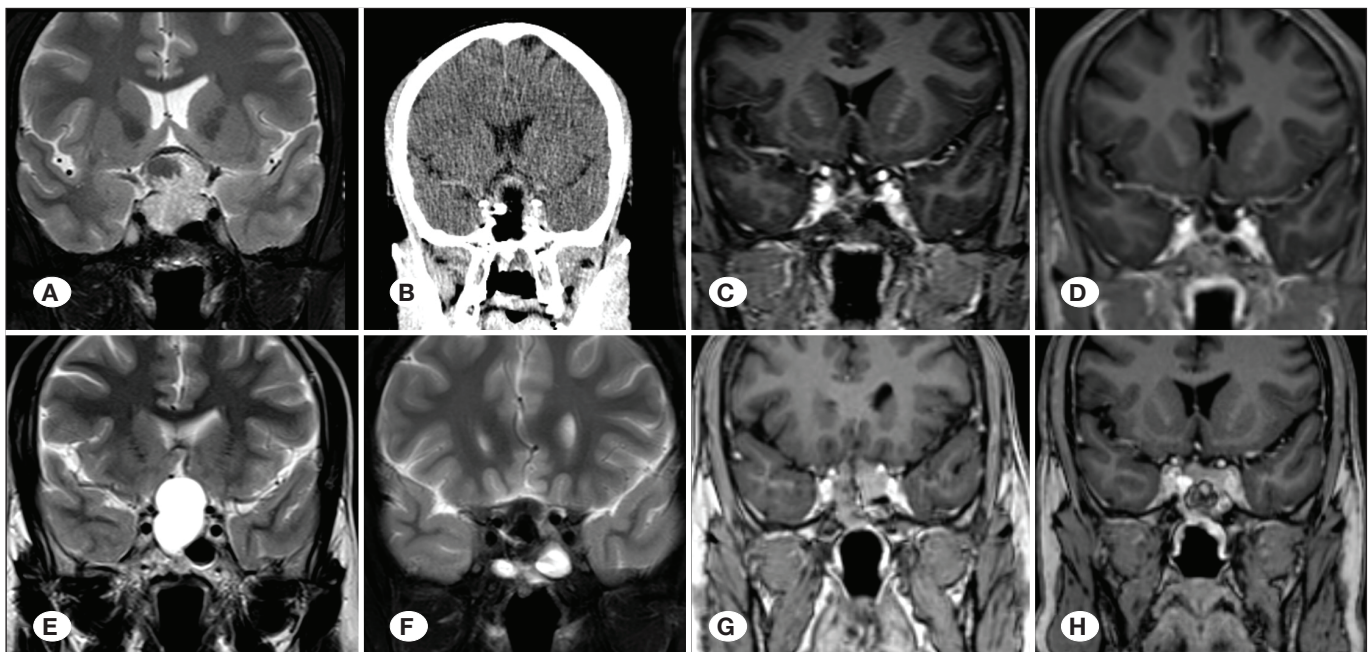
Coronal T2-weighted MRI showing a 3.7 cm pituitary macroadenoma displaying microcystic changes and evidence of haemorrhage in the superior aspect of the tumour (A). No obvious residual tumour was seen on the first postoperative contrast-enhanced CT done 5 days after surgery (B); The tumour did not recur at 6 months (C), and 14 months (D) after surgery, however a 2.8 cm large, CSF-intensity cyst in the sellar and suprasellar region causing compression of the optic chiasm was seen at the 40-month follow-up (E), for which he was reoperated and remained free of recurrence a year later (F). However, he presented 68 months later with a large recurrence (G), and features of Cushing disease. He underwent a repeat transsphenoidal resection followed by stereotactic radiation therapy for the residue (H).
